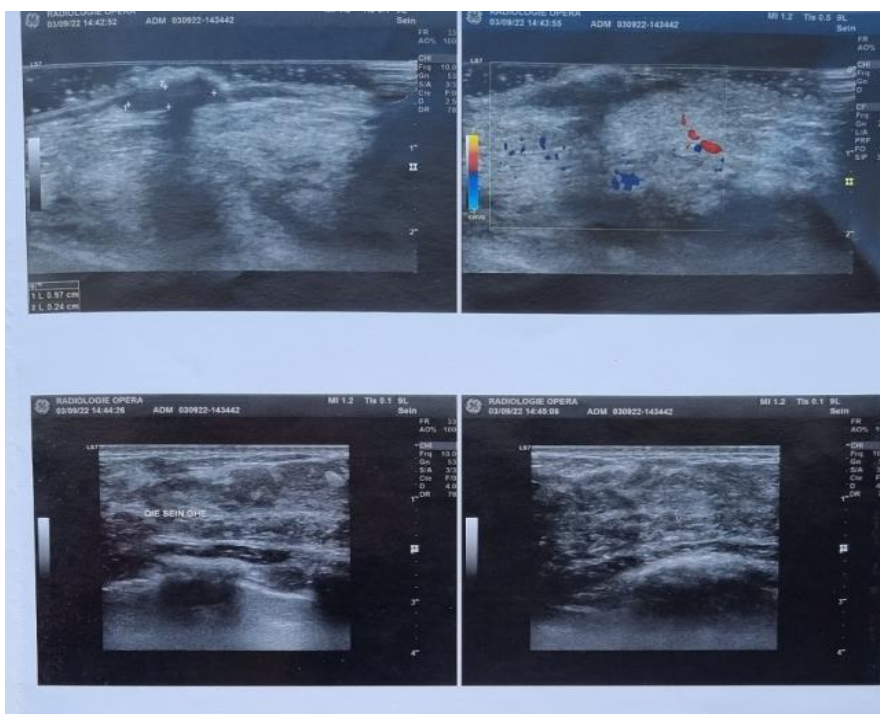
Ultrasound of the left breast showing a swelling of the superior-internal quadrant with avascular hypoechoic skin thickening with respect of the subcutaneous fatty plane without sign of retraction and absence of axillary adenopathy.
